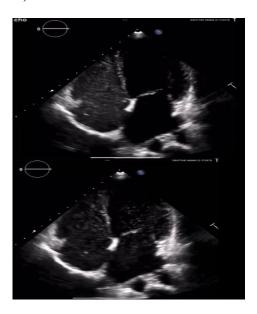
Contrast echocardiography study significant bubbling in LA and LV from RA after 5th cardiac cycle hinted towards an significant right to left extracardiac shunt.
